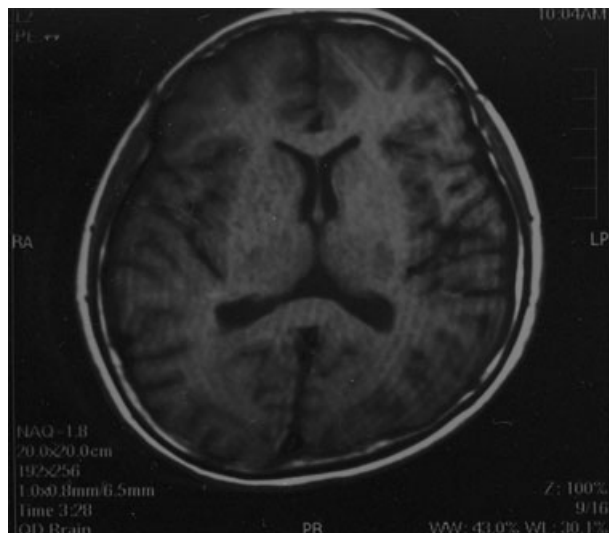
Brain magnetic resonance imaging showing slight atrophy with multiple cerebral infarctions.
